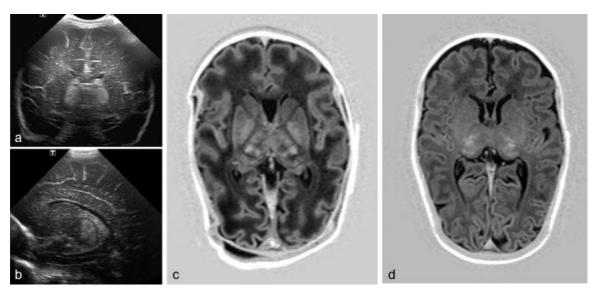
Male infant, gestational age 34 weeks. (a) Coronal and (b) parasagittal ultrasound scans performed on day 1, showing bilateral thalamic echogenicity. (a) Axial magnetic resonance imaging T1-weighted images in the first week (c) and (d) at term-equivalent age (TEA) show increased signal intensity in the thalami. At TEA (d), the thalami look small and there is no myelination of the posterior limb of the internal capsule.
